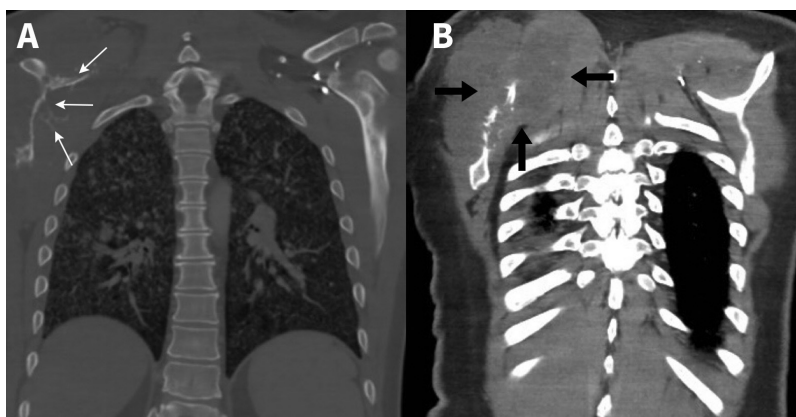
Noncontrast enhanced computed tomography scans of a 38-year-old man's thorax. Coronal reconstructions on the thorax using bone (A) and soft-tissue (B) algorithms showed extensive destruction of the right scapula (thin arrows) from osteomyelitis and a surrounding, multiloculated abscess extending from the scapula to the supraclavicular fossa (thick arrows).
